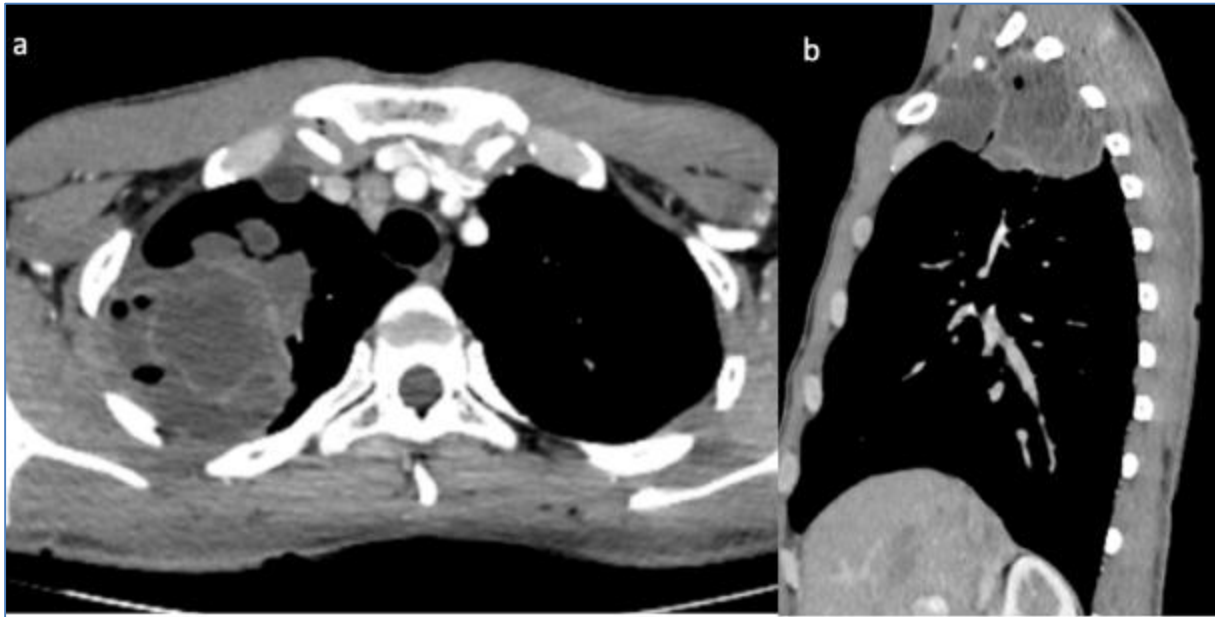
Axial (a) and sagittal (b) thin-section enhanced cervicothoracic computed tomography scan showing a large right apical cystic mass containing membranes and gas with cervical extension and innominate venous trunk compression
